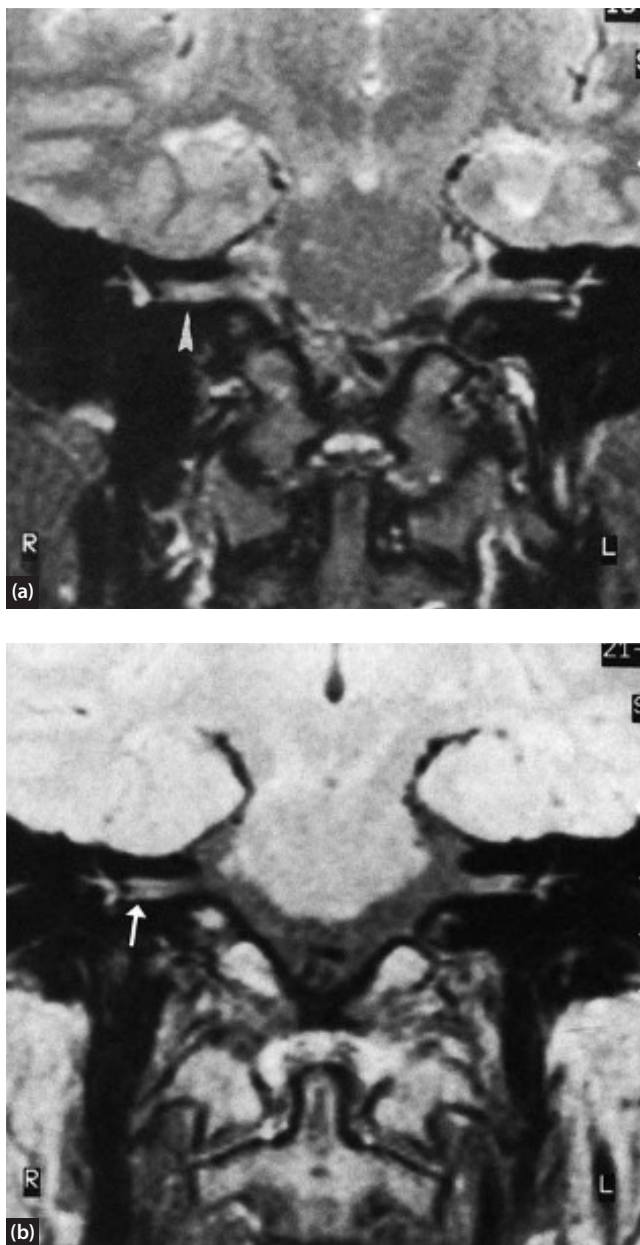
(a) Coronal T2-weighted MRI: mild enlargement of the right VIIIth nerve inside the internal auditory canal, and punctate area of hyperintense signal (arrow). (b) Coronal T2-weighted MRI: no lesion seen along the right VIIIth cranial nerve. (c) ABR recordings (rarefaction clicks, 65 dB SL intensity, 22.1 Hz frequency, Cz–A2 electrodes) before (A), and after (B–L), right sudden hearing loss. Reproduced with permission.³⁷
